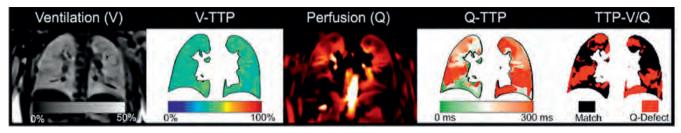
PREFUL MRI depicts the typical V/Q mismatch of a CTEPH patient and shows increased Q-TTP.
